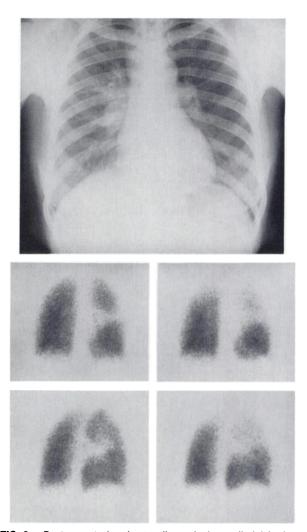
Postero-anterior chest radiograph shows diminished activity over right mid zone and right upper zone. Posterior and right posterior oblique views of ventilation scans (top) show diminished activity over right mid zone. Similar views of perfusion scans (bottom) show diminished activity over right upper and mid zones.
